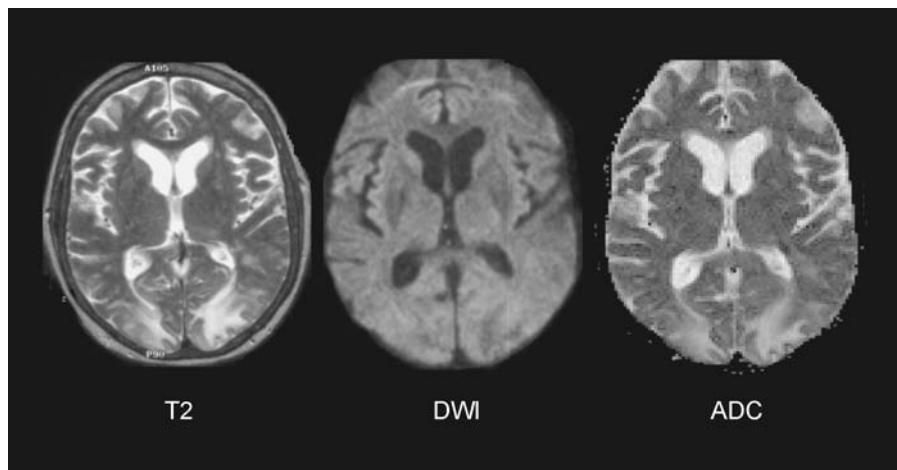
Posterior reversible encephalopathy syndrome (PRES). Fifty-six-year-old hypertensive female with visual changes and question of a basilar tip syndrome. T2-weighted images demonstrate hyperintense lesions in the occipital lobes bilaterally that suggest acute infarctions. The lesions are isointense on DWI images and hyperintense on ADC images. These diffusion MR characteristics are consistent with vasogenic edema. Abbreviations: DWI, diffusion-weighted images; ADC, apparent diffusion coefficient; MR, magnetic resonance.
